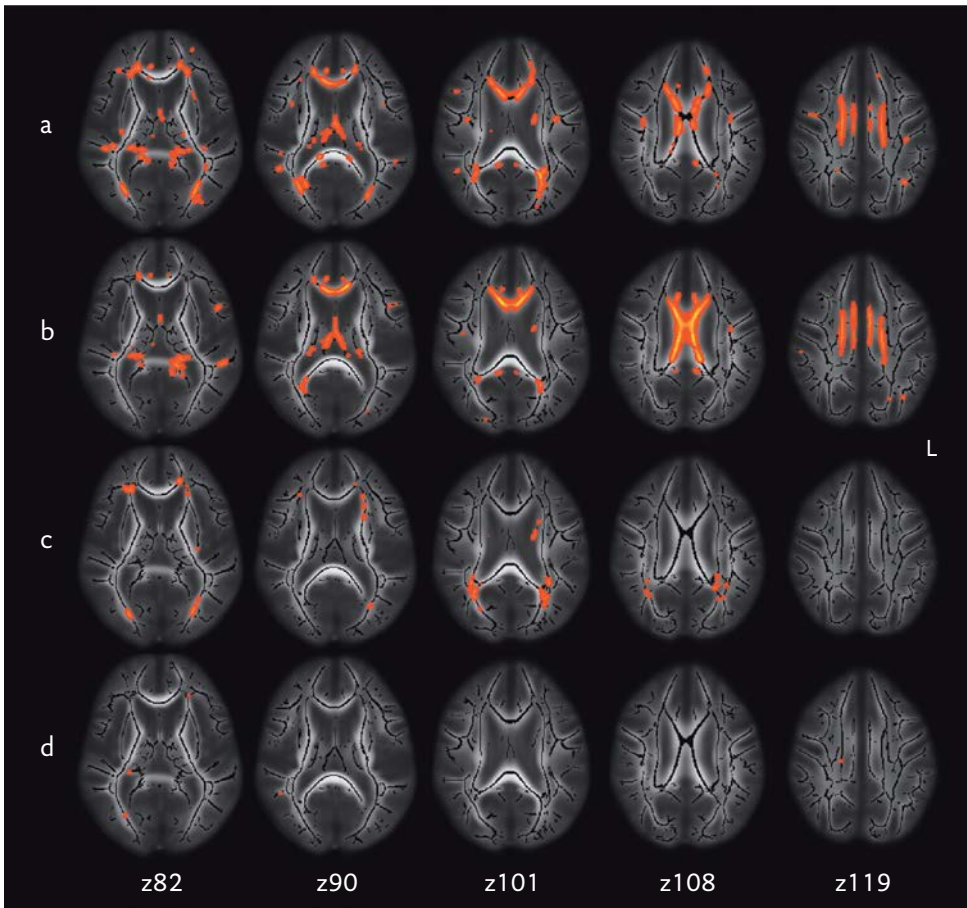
Effects of age, global white matter atrophy and white matter lesions on fractional anisotropy values of normal-appearing white matter. Images are shown in the Montreal Neurological Institute (MNI) stereotactic space, with MNI coordinates for axial levels (z) depicted for each column. The white matter skeleton (black) is projected onto the axial MR images. Yellow-to-red colors represent normal-appearing white matter regions with reduced fractional anisotropy (FA) in relation to (a) increasing age, adjusted for sex only, (b) global white matter atrophy, adjusted for age, sex and white matter lesions, (c) white matter lesions, adjusted for age, sex and white matter atrophy and (d) increasing age, adjusted for sex, white matter atrophy and white matter lesions. With increasing age, multiple regions show significant decreases in FA (a). However, after adjustment for white matter atrophy and white matter lesions, only few regions remain (d). Global white matter atrophy (b) relates to decreases in FA in the hippocampal region (z82), fornix (z90), corpus callosum (z90 to z108) and along the cingulate bundle (z119). In contrast, white matter lesion burden (c) is associated with reduced periventricular FA (z82 to z108).
